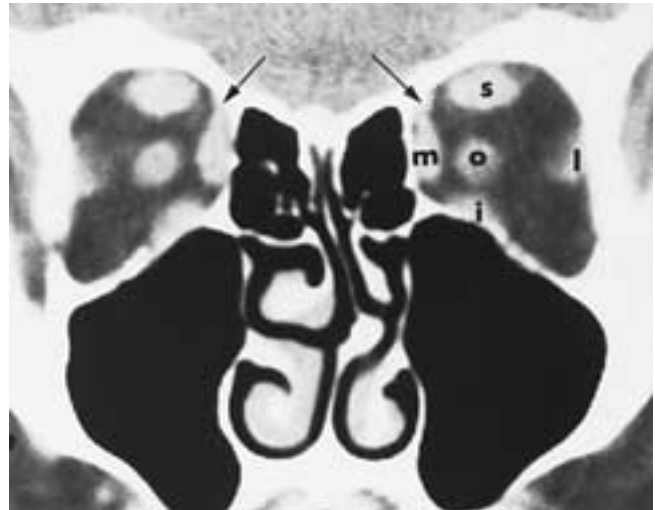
Extraocular muscles. Coronal CT scan shows inferior rectus muscle (*i*); lateral rectus muscle (*l*); medial rectus muscle (*m*); and superior rectus muscle (*s*). Note the superior oblique muscles (*arrows*) and optic nerve (*o*).
